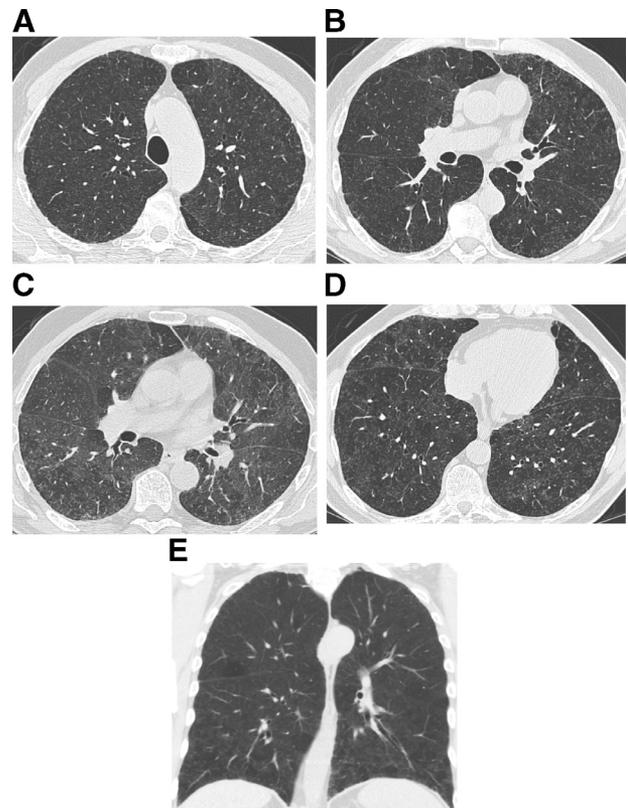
Axial (A-D) and coronal (E) images from HRCT demonstrate diffuse ground glass opacity in a centrilobular configuration and basilar mosaic attenuation, consistent with a non-IPF diagnosis (formerly inconsistent with UIP). The constellation of findings is highly suggestive of HP.
